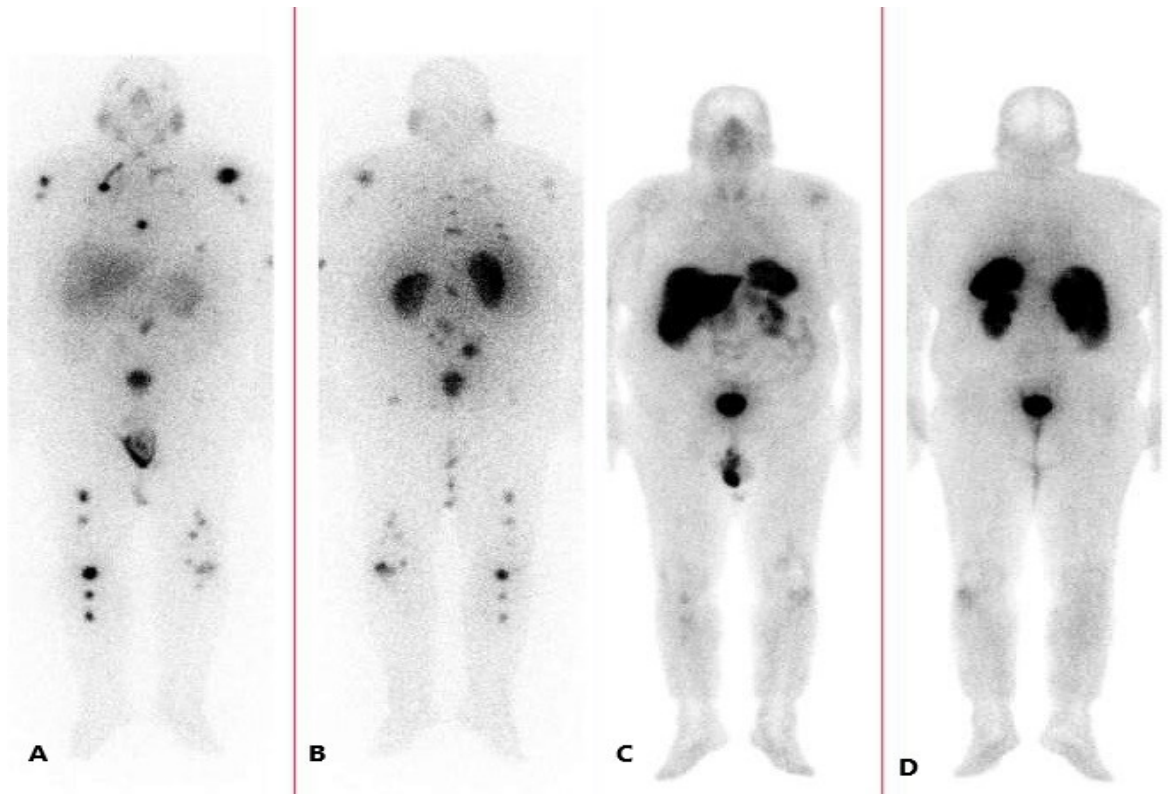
Whole-body post-therapy 177Lu-PSMA scan (A: anterior and B: posterior) shows multiple skeletal metastases. Whole-body 99mTc-octreotide scan (C: anterior and D: posterior) reveals minimal abnormal uptake around the knees and left shoulder, corresponding to the known metastatic lesions.
